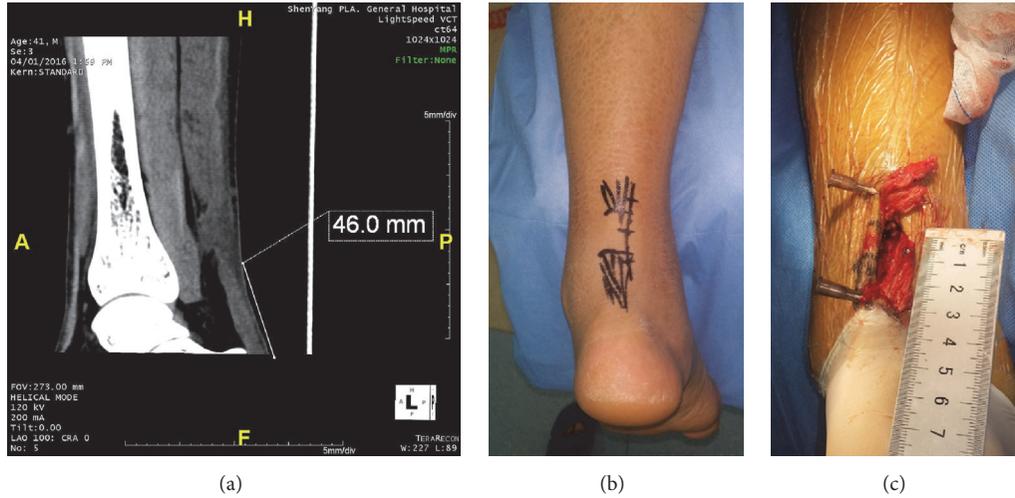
41-year-old male. (a) Adjusting the axis of images through the MPR module and measuring the length of distal part. (b) Locating the rupture position by the distance from the calcaneal insertion of AT measured in CT MPR images. (c) Measuring the length of distal part intraoperation directly.
